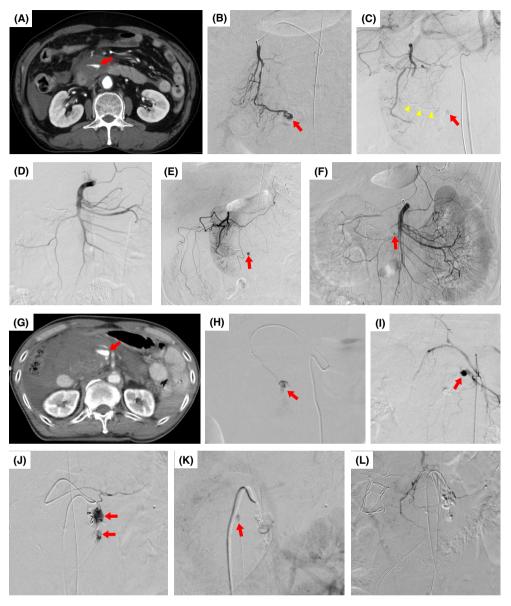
A–F, Imaging of a 63-year-old man with traumatic pancreaticoduodenal artery injury. A, Contrast-enhanced computed tomography (CT) showing a pancreatic head hematoma with extravasation (arrow) in the arterial phase. B, Angiography of the posterior superior pancreaticoduodenal artery (PSPDA) in the first angiography session showed extravasation. C, Celiac artery (CA) angiography showed a cast-like embolization of PSPDA (arrowheads) and disappearance of extravasation, although a pseudoaneurysm of unknown origin (arrow) appeared after embolization with n-butyl-2-cyanoacrylate (NBCA). D, Superior mesenteric artery (SMA) angiography after PSPDA embolization showed no pseudoaneurysm. E, Gastroduodenal arteriography in the second angiography session after stabilization in the intensive care unit showed a residual pseudoaneurysm (arrow), although the culprit vessel could not be identified. F, The final SMA angiograph also shows a residual pseudoaneurysm (arrow) without identification of the culprit vessel. G–L, Imaging of a 67-year-old man with traumatic pancreaticoduodenal artery injury. G, Initial contrast-enhanced CT of the arterial phase showing massive extravasation of the pancreatic head (arrow). H, Extravasation is seen on PSPDA angiography from the CA side in the first angiography session (arrow) and embolized with NBCA. I, Extravasation is seen at the inferior pancreaticoduodenal artery through the CA side is seen in the second angiography session (arrow), and embolized using NBCA in combination with microcoils. J, Rebleeding from the dorsal pancreatic artery through the CA side is seen in the second angiography session (arrow), but it was difficult to identify the culprit vessel. L, In the third angiography session, extravasation disappeared in both CA and SMA angiographies.
